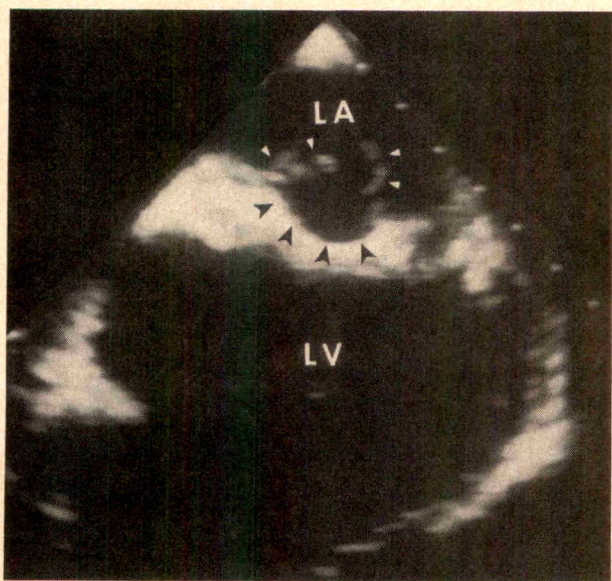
Close-up view of a Starr-Edwards mitral prosthesis by transesophageal echocardiography in a 16-year-old patient with sepsis. Large mobile linear structures (white arrowheads) are attached to either side of the sewing ring (black arrowheads), the typical appearance of vegetation. LA = left atrium; LV = left ventricle.
